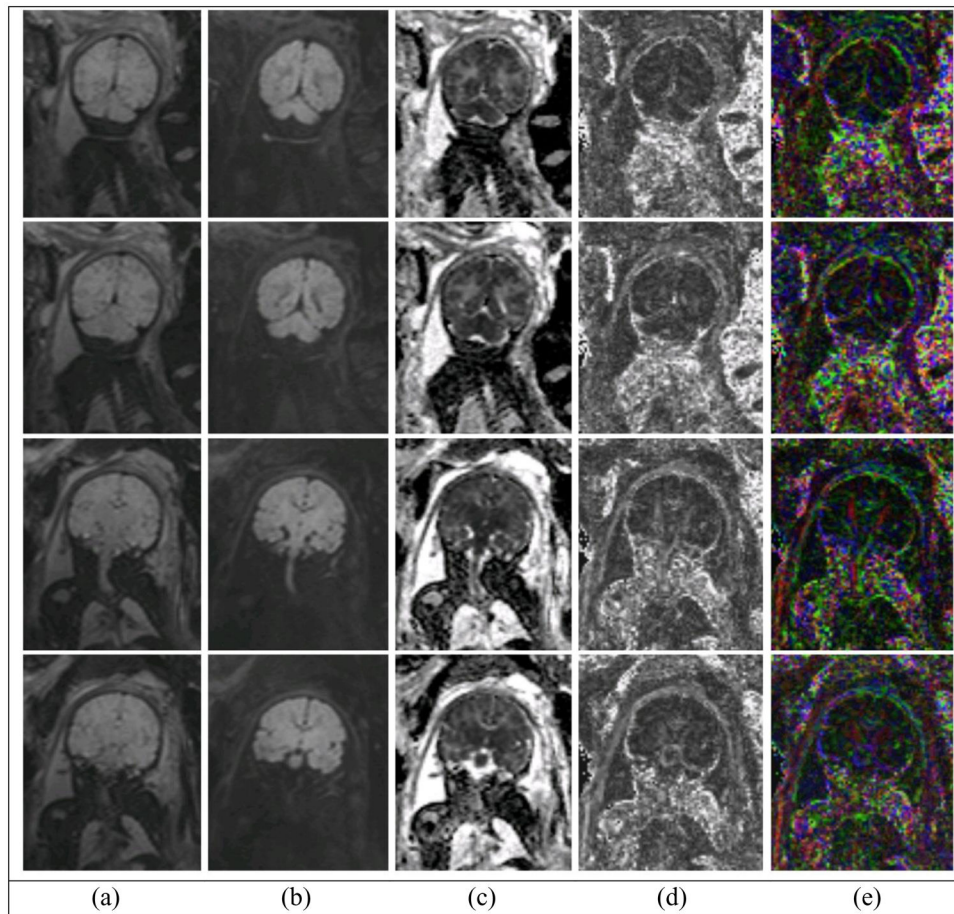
Coronal DWI slices of a 39 week gestation age fetus acquired on a Philips Achieva 1.5 T scanner (DWI with high b value of 500 s/mm^2 and 6 gradient directions); (a) $b=0$ image, (b) DWI image, (c) ADC, (d) FA, and (e) color FA. FA and color FA maps are apparently more sensitive to motion as compared to the ADC map. Motion correction is critical in the analysis of fetal DWI scans.
